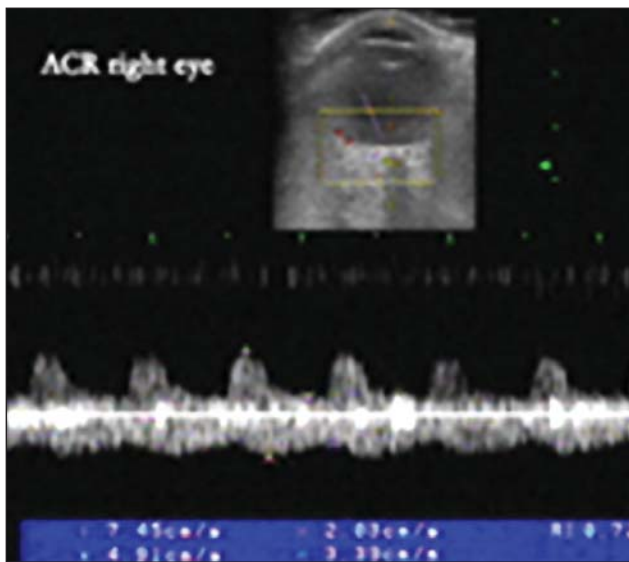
b. Patient MM-Spectral Doppler analysis of central retinal arteries (CRA).
